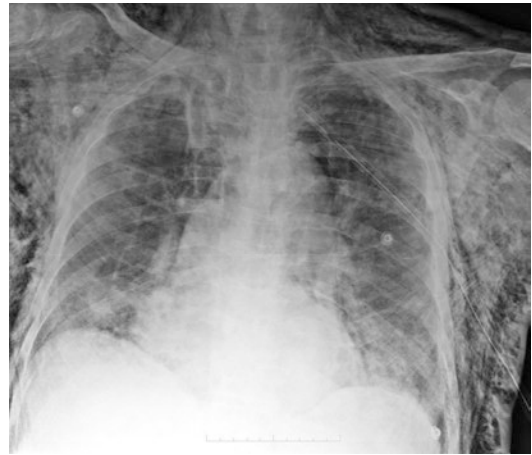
Chest radiograph shows extensive subcutaneous emphysema diffused into shoulders and chest fat planes; it is also present pneumo-mediastinum, with multiple lucencies along mediastinal planes
